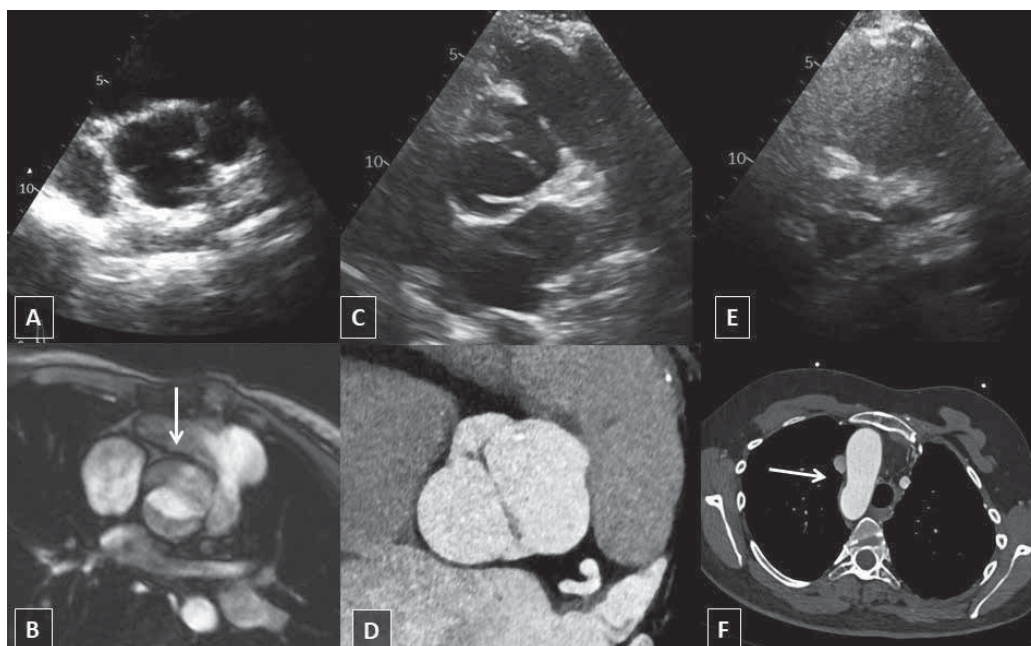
A, C, E. Patients 1–3, respectively. Echocardiography. The bicuspid aortic valve with fused coronary cusps. B. Patient 1. Cardiac magnetic resonance with focus on the bicuspid aortic valve (the white arrow). D. Patient 2. Chest computed tomography. The bicuspid aortic valve without raphe. F. Patient 2. Chest computed tomography. The right aortic arch (the white arrow)
